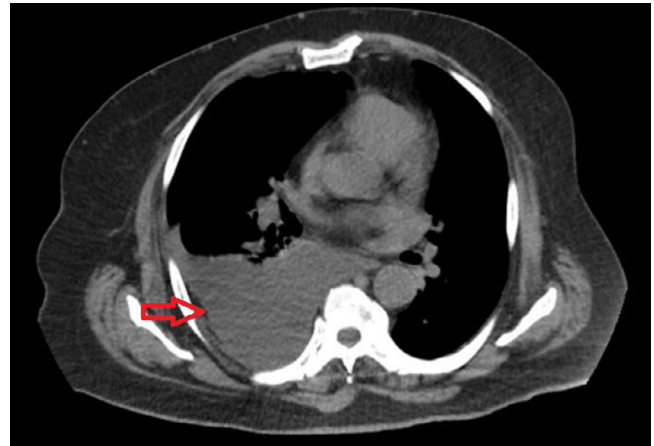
CT chest without contrast reveals large right-sided pulmonary effusion (red arrow).
